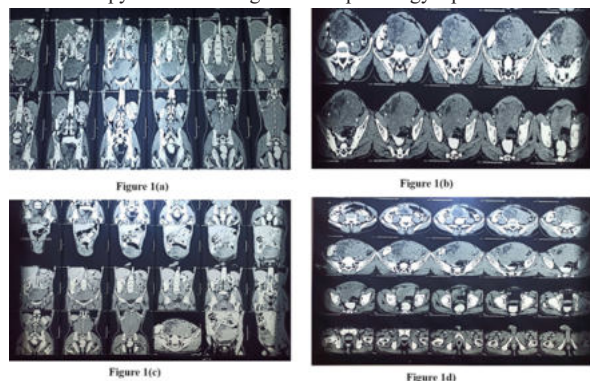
(a,b,c and d) Axial, coronal and sagittal sections of the Abdominal and Pelvis CT scan revealed a large mass arising from the pelvis with rather uniform density and a regular well-defined outline. There are some areas of central necrosis.
